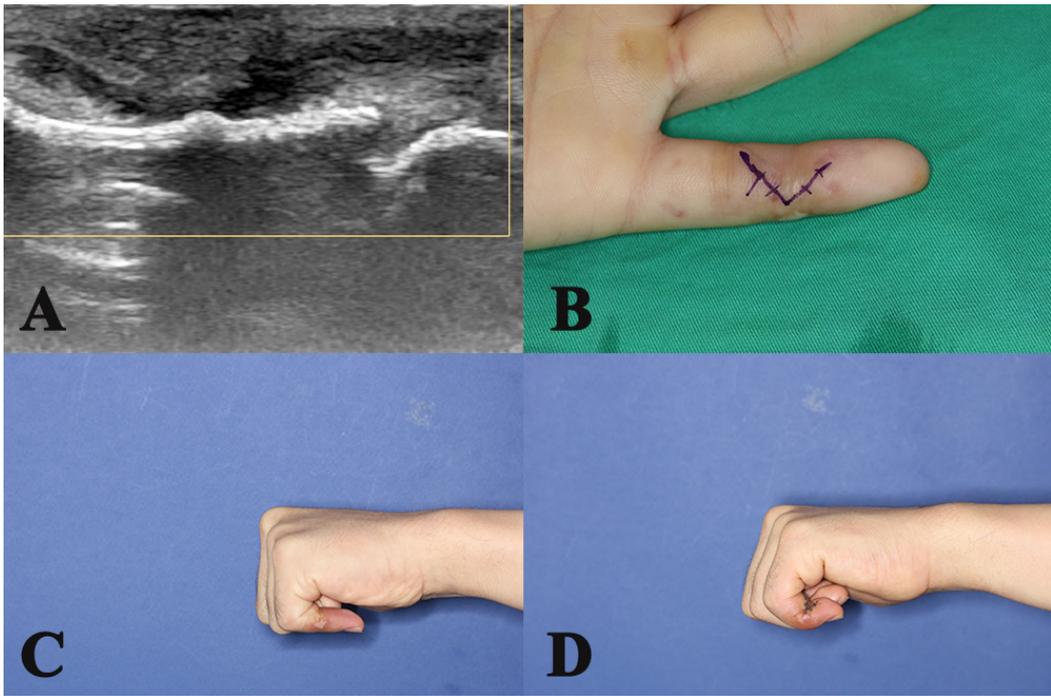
A) Pre-operative ultrasonography (chronic rupture of FDP at middle phalangeal shaft with soft tissue mass-like lesion in gap of the ruptured and retracted tendon is noted), B) Pre-operative view of the completely healed little finger, C) Pre-operative range of motion, D) Post-operative range of motion (Patient no.4, Little finger)
